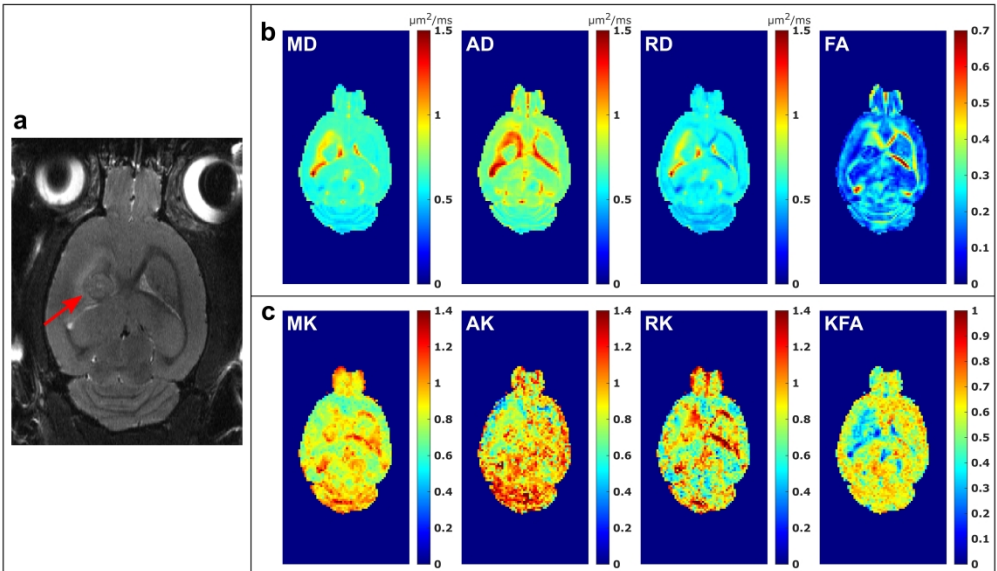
Representative T2-weighted image (a) and its corresponding diffusivity (b) and kurtosis (c) parametric maps. The red arrow indicates the tumor location on the T2-weighted image.
